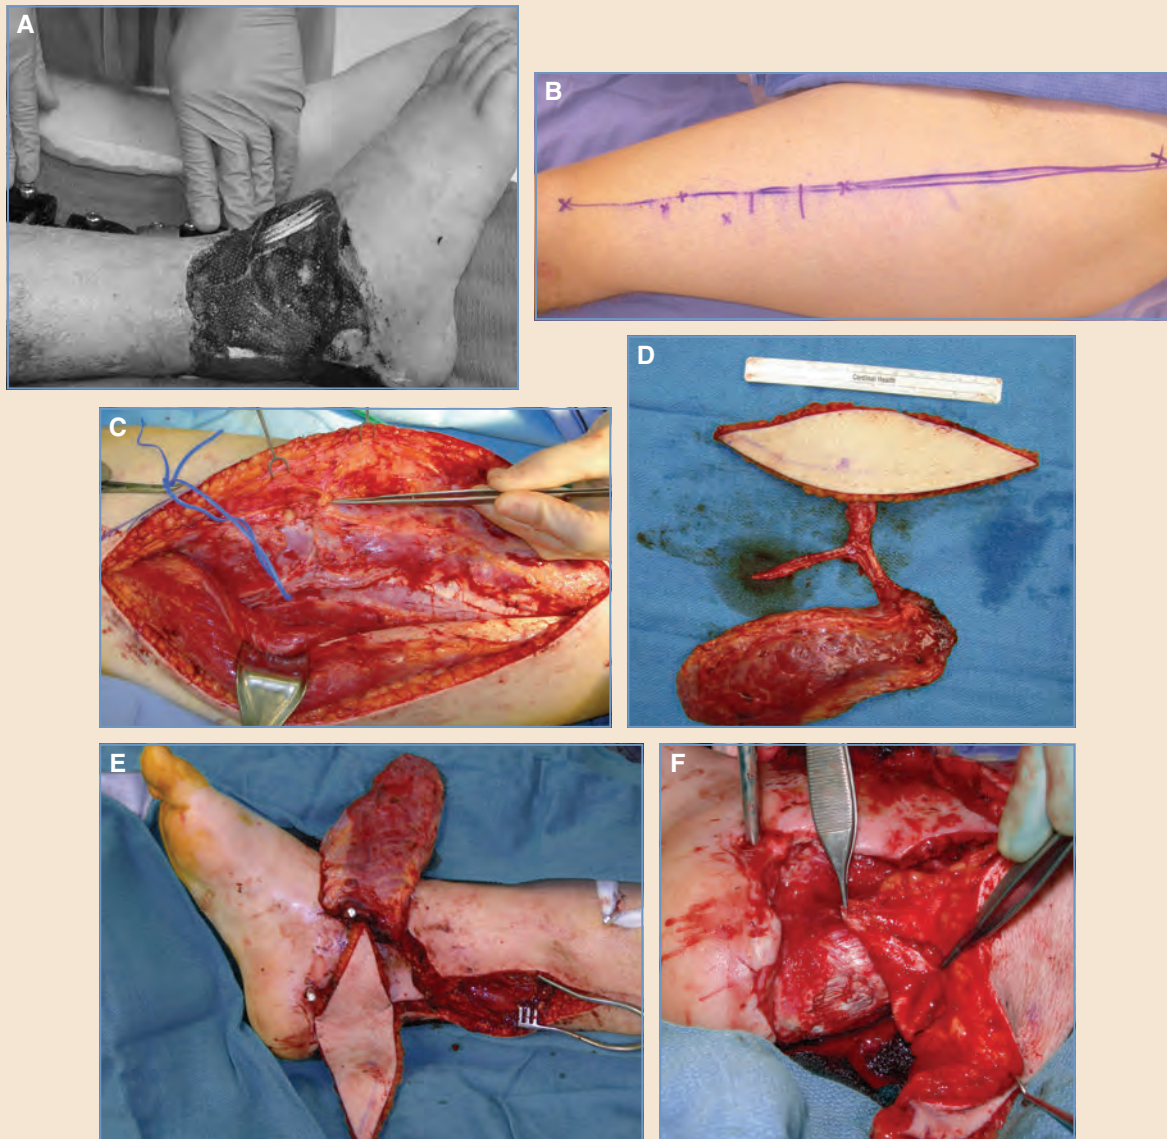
A, This patient had an open dislocation of the right ankle with loss of soft tissue coverage. The wound was nearly circumferential. The ankle joint was stabilized with an external fixator. B, The intermuscular septum between the vastus lateralis and rectus femoris muscles of the left thigh was marked. Cutaneous vessels were identified with a handheld Doppler probe and their positions marked. C, The descending branch of the lateral circumflex femoral artery was identified between the vastus lateralis and rectus femoris muscles. The vessel penetrated the vastus lateralis muscle as it coursed distally in the thigh. A branch that coursed to the skin was identified within the intermuscular septum. D, An anterolateral thigh flap and a partial vastus lateralis flap were raised from the left thigh with a common pedicle (the descending branch of the lateral circumflex femoral artery and vein). Generous pedicle length is a useful feature of these flaps. E, Anastomosis to the posterior tibial vessels was performed, and a flap inset was planned. F, A segment of fascia lata included on the deep surface of the skin paddle was used as a vascularized fascia flap for reinforcement of the compromised Achilles tendon.
